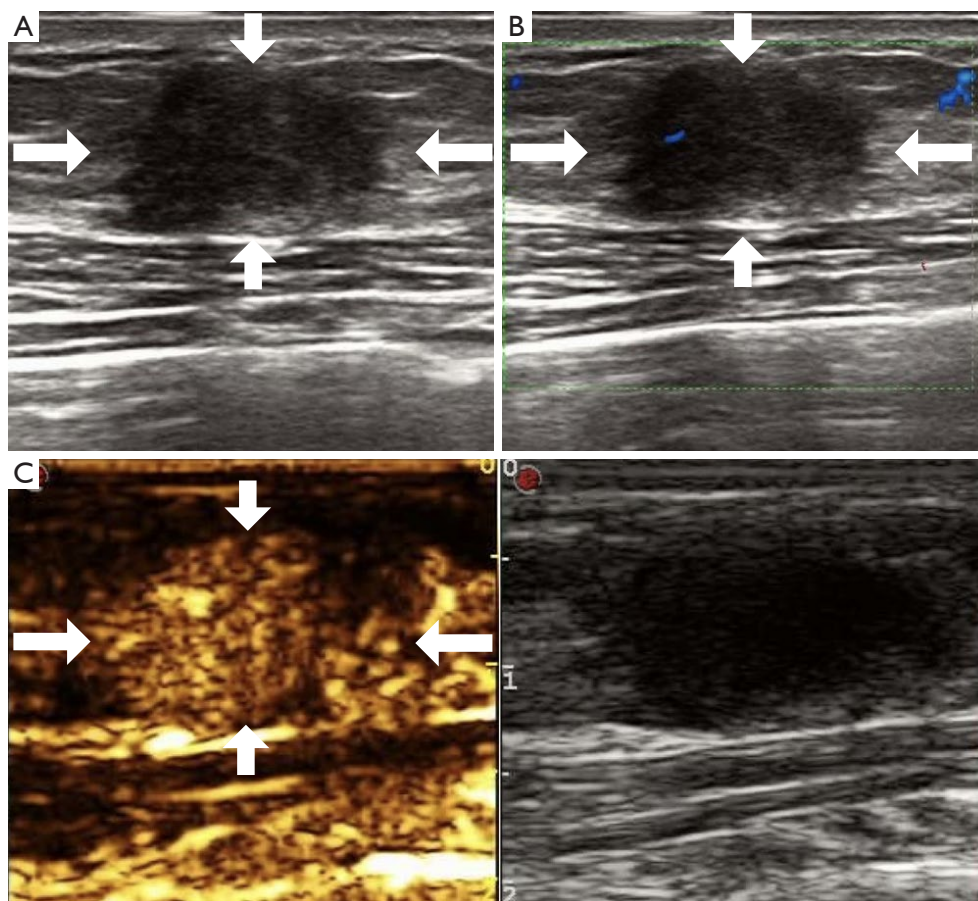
A 43-year-old woman with breast cancer on the left side. (A) B-mode ultrasound image showed irregular echogenic lesions in the mammary gland with unclear boundaries (white arrows). (B) Color Doppler flow imaging showed grade I blood flow distribution* (white arrows); (C) CEUS showed an unseen enlargement of the lesion (white arrows). *, according to Adler blood flow grading results. CEUS, contrast-enhanced ultrasound.
